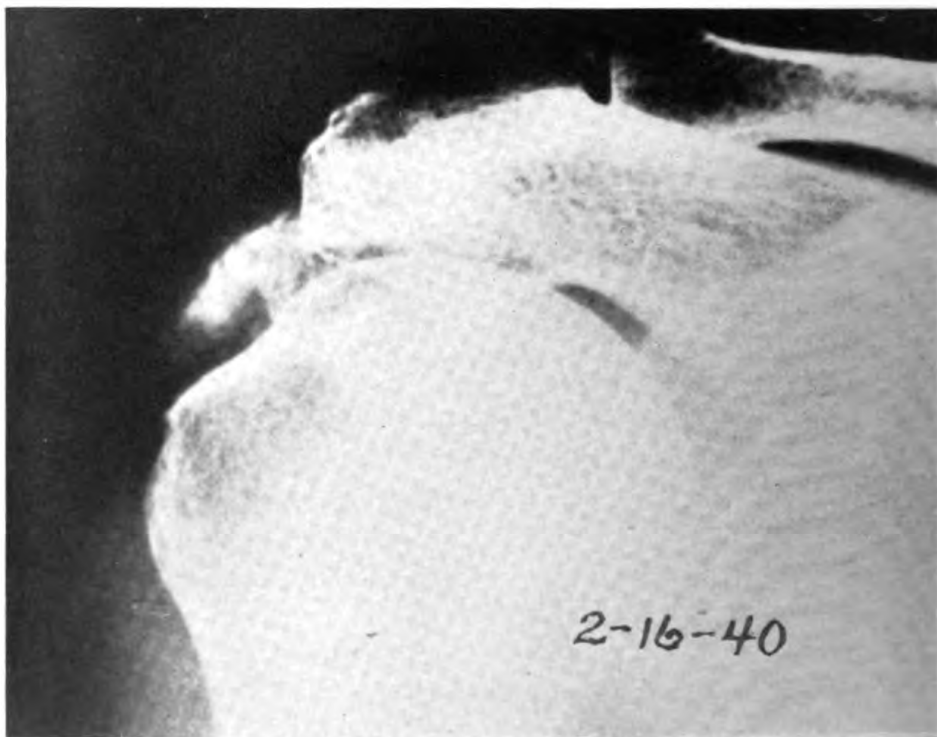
CASE 22.—AFTER 5 DOSES OF 100 ROENTGENS EACH.
